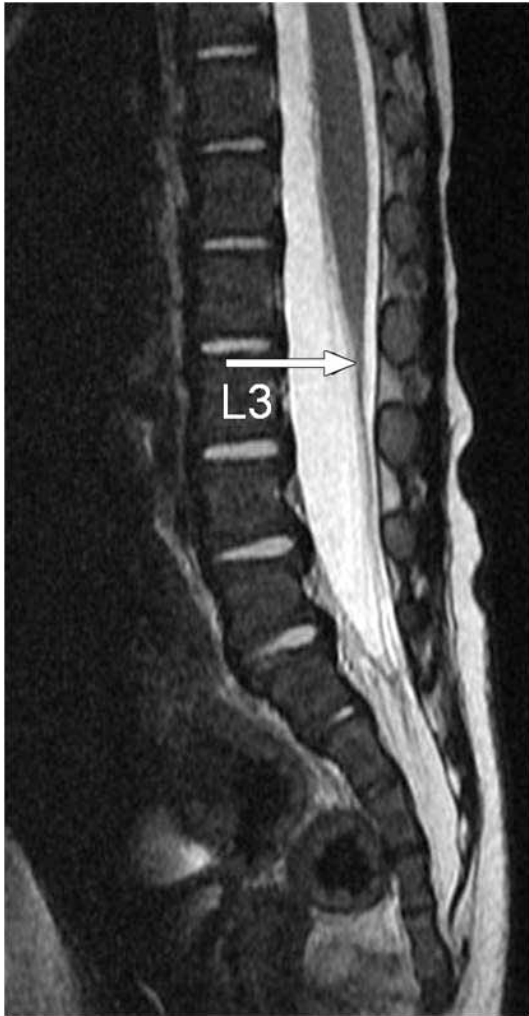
Sagittal-T2 MR image shows a low-lying conus (arrow) that ends at L3.
